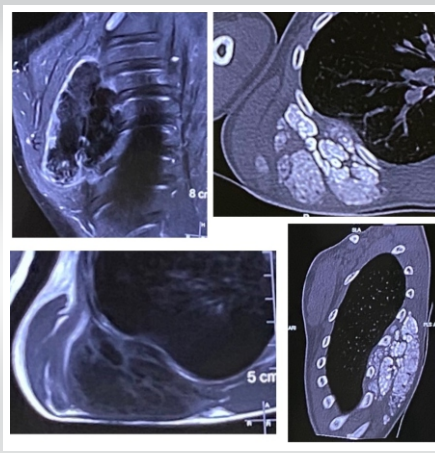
Pre-operative magnetic resonance imaging/computed tomography.
